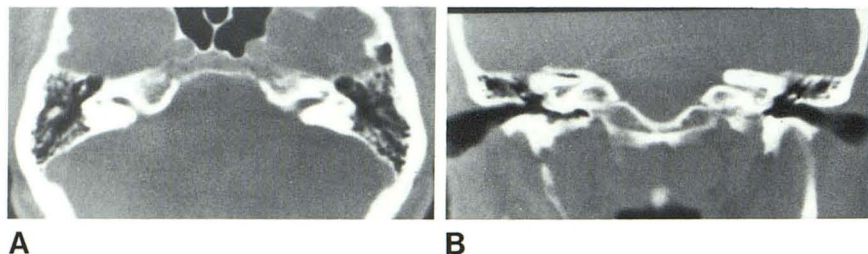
Anteverted internal auditory canals. A, Axial CT shows symmetrically anteverted canals with slight, anteriorly convex curve. Mild brachycephaly. B, Coronal CT shows effect of thin sectioning on angled cylinder. Canals show apparent medial narrowing, which is artifactual.
